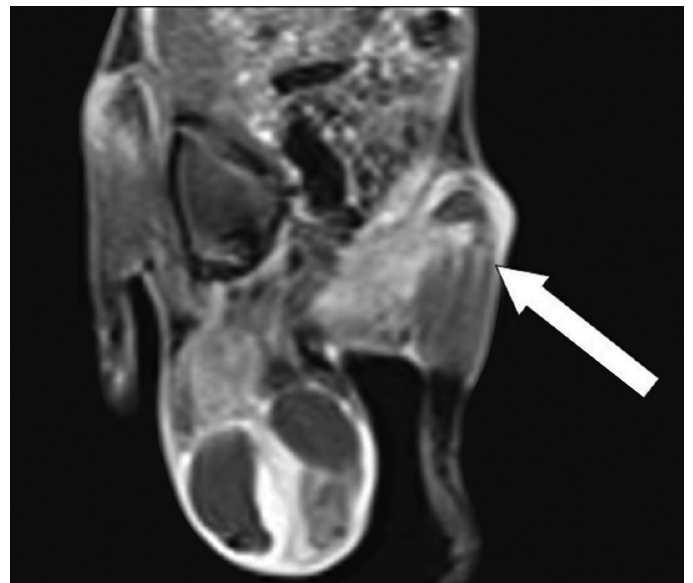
Contrast T1 MRI showing significant contrast enhancement MRI: Magnetic Resonance Imaging
